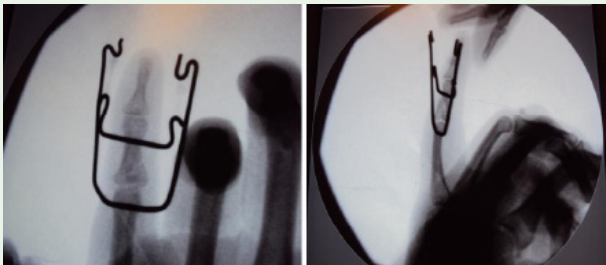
Intraoperative X-ray image of the fracture.
